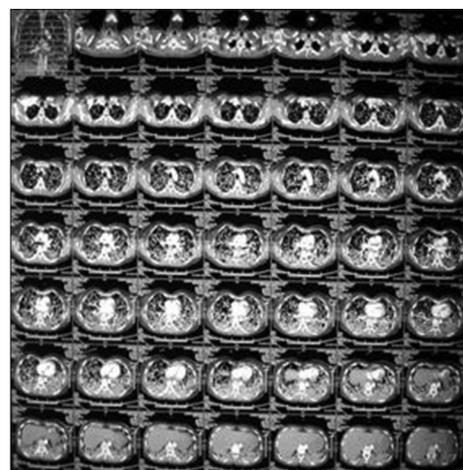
Axia chest computed tomography-scan showing multiple bilateral nodular lesions
